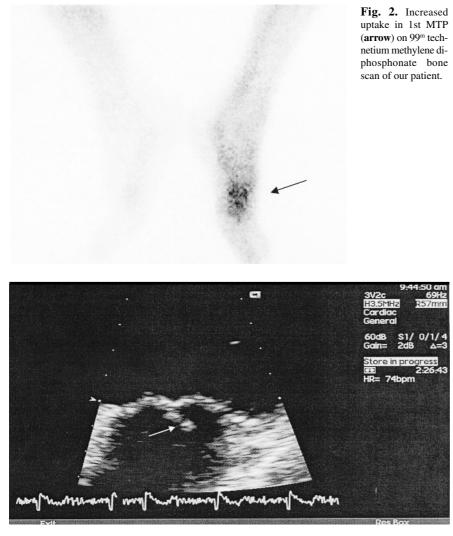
Vegetation on the mitral valve (arrow) on the transthoracic echocardiogram of our patient.
